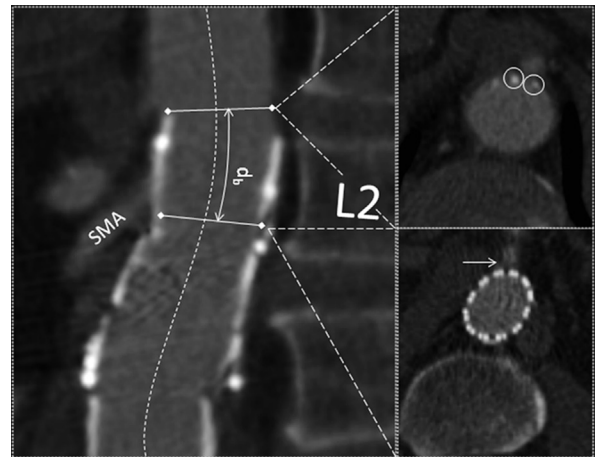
A proximal measurement (d_b) has been undertaken using the baseline central luminal line (CLL) computed tomography (CT) image. The first oblique axial reformatted image, where at least two stents struts were visible (circles), was considered indicative of the proximal stent position. The first reformatted slice where there was a clear space between the superior mesenteric artery (SMA) and the aortic wall was considered the inferior border of the reference vessel (arrow). Lines perpendicular to the CLL demonstrate the projection of each oblique reformat and indicate the central point within each reconstructed slice.
